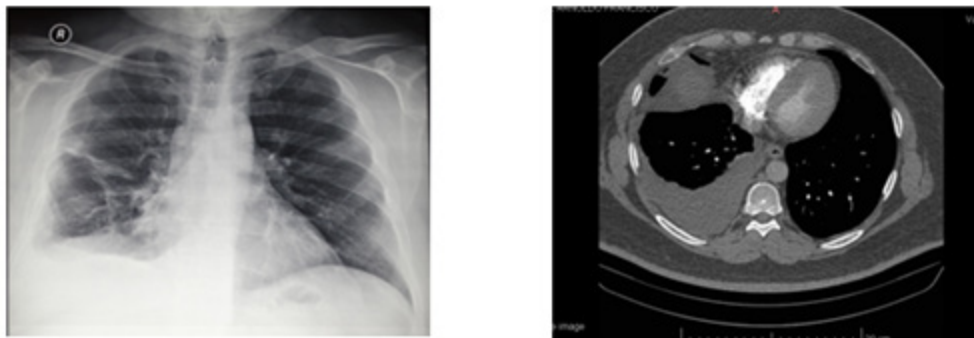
Chest X-ray and Chest CT on admission (10/10/2016).
